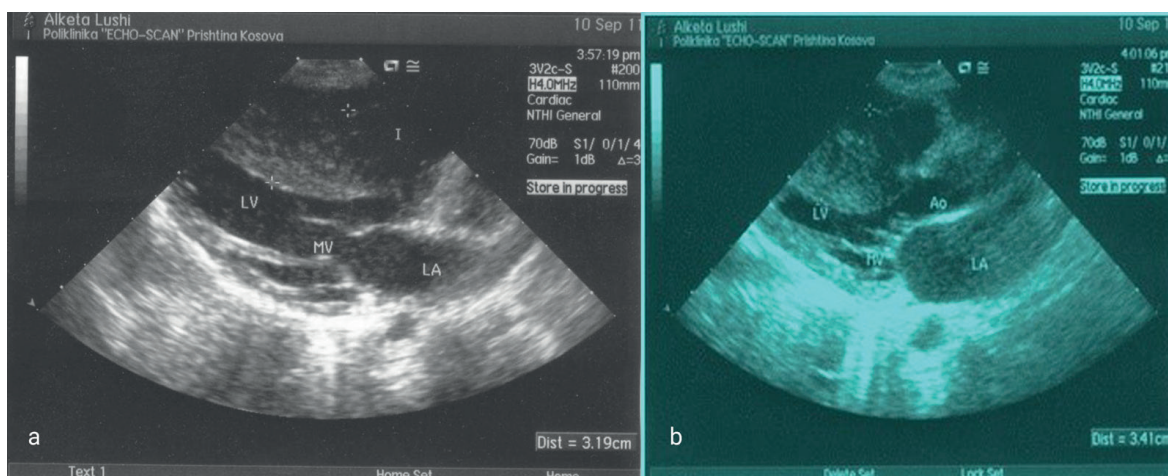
Parasternal left ventricular long-axis echocardiographic section obtained a patient in diastole (a) and systole (b) with hypertrophic cardiomyopathy.
